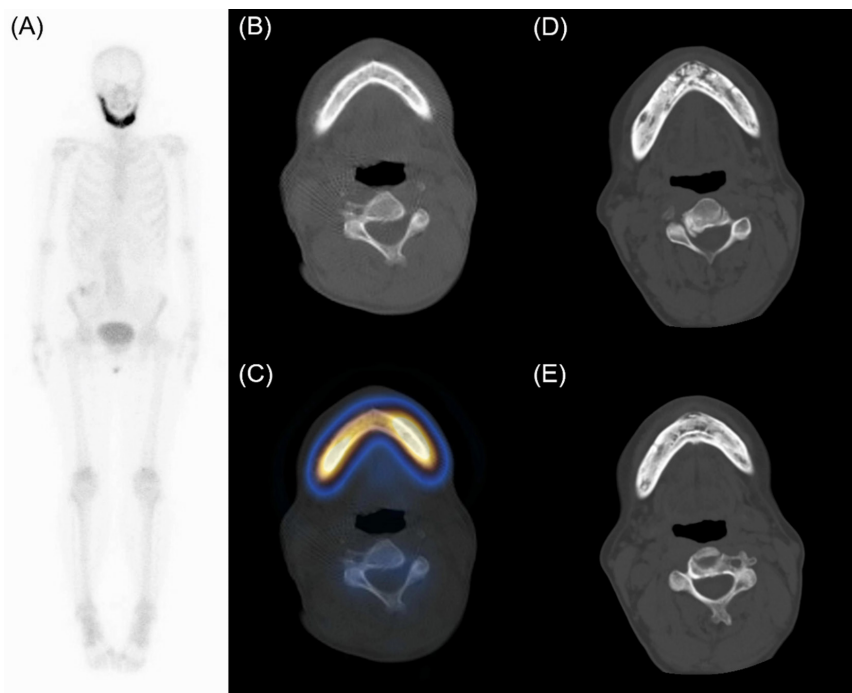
A 52-year-old woman, who was known to have stage IV breast cancer with metastasis to bone and liver and was administered a subcutaneous injection of denosumab for 7 years, presented with gradual onset of non-mobile submental hard mass and oral ulcer. There was no history of radiation therapy or metastatic disease of the jaws. The patient was referred for Tc-99m-methylene diphosphonate (MDP) bone scintigraphy to rule out progression of bone metastasis. Whole-body Tc-99m-MDP bone scintigraphy showed marked diffuse tracer uptake in the mandible, resembling the Lincoln sign (A). Single photon emission computed tomography/computed tomography (CT) demonstrated diffuse sclerosis with periosteal reaction in the mandible (B, C). No other abnormal bony tracer uptake focus was observed. Physical examination by a dental surgeon revealed bilateral orocutaneous fistulas at the lower border of the mandible with exposed bone. A clinical diagnosis of stage III medication-related osteonecrosis of the jaw (MRONJ) was made. Denosumab was discontinued immediately. The patient opted for conservative therapy with limited debridement and oral rinses with chlorhexidine. A subsequent CT study performed three years later showed diffuse sclerotic appearance of the mandible with multiple irregular lucency in the mandibular body and cortical bone loss (D, E), consistent with MRONJ. MRONJ is a potentially serious complication of bone modifying agent (BMA), which is more common in patients with advanced malignancy than in patients with osteoporosis (1). The cumulative incidence rates of MRONJ increase with longer duration of BMA exposure, with an incidence of 0.7%-1.4% during the first year of therapy and increasing to 2%-3.4% with continued treatment beyond one year (2). Other risk factors of MRONJ include previous oral surgery, periodontal disease, use of dentures, smoking, angiogenesis inhibitors, and diabetes (3). MRONJ can be classified into stages I-III, depending on the presence of exposed and necrotic bones, fistulas that probe to bone, symptoms, evidence of infection, and extent of lesions (3). Symptomatic treatment with antibacterial mouth rinse and analgesics can be administered to patients with early-stage disease, whereas surgical debridement or resection may be required for those with advanced-stage disease. The Lincoln sign on bone scintigraphy is characteristic of monostotic Paget's disease of the mandible and is less commonly observed in primary mandibular tumors (4), contiguous spread of oral malignancies (4), or distant metastases to the mandible (5). The Lincoln sign has not been reported in MRONJ previously, and this condition should be considered in cancer patients treated with BMA.
